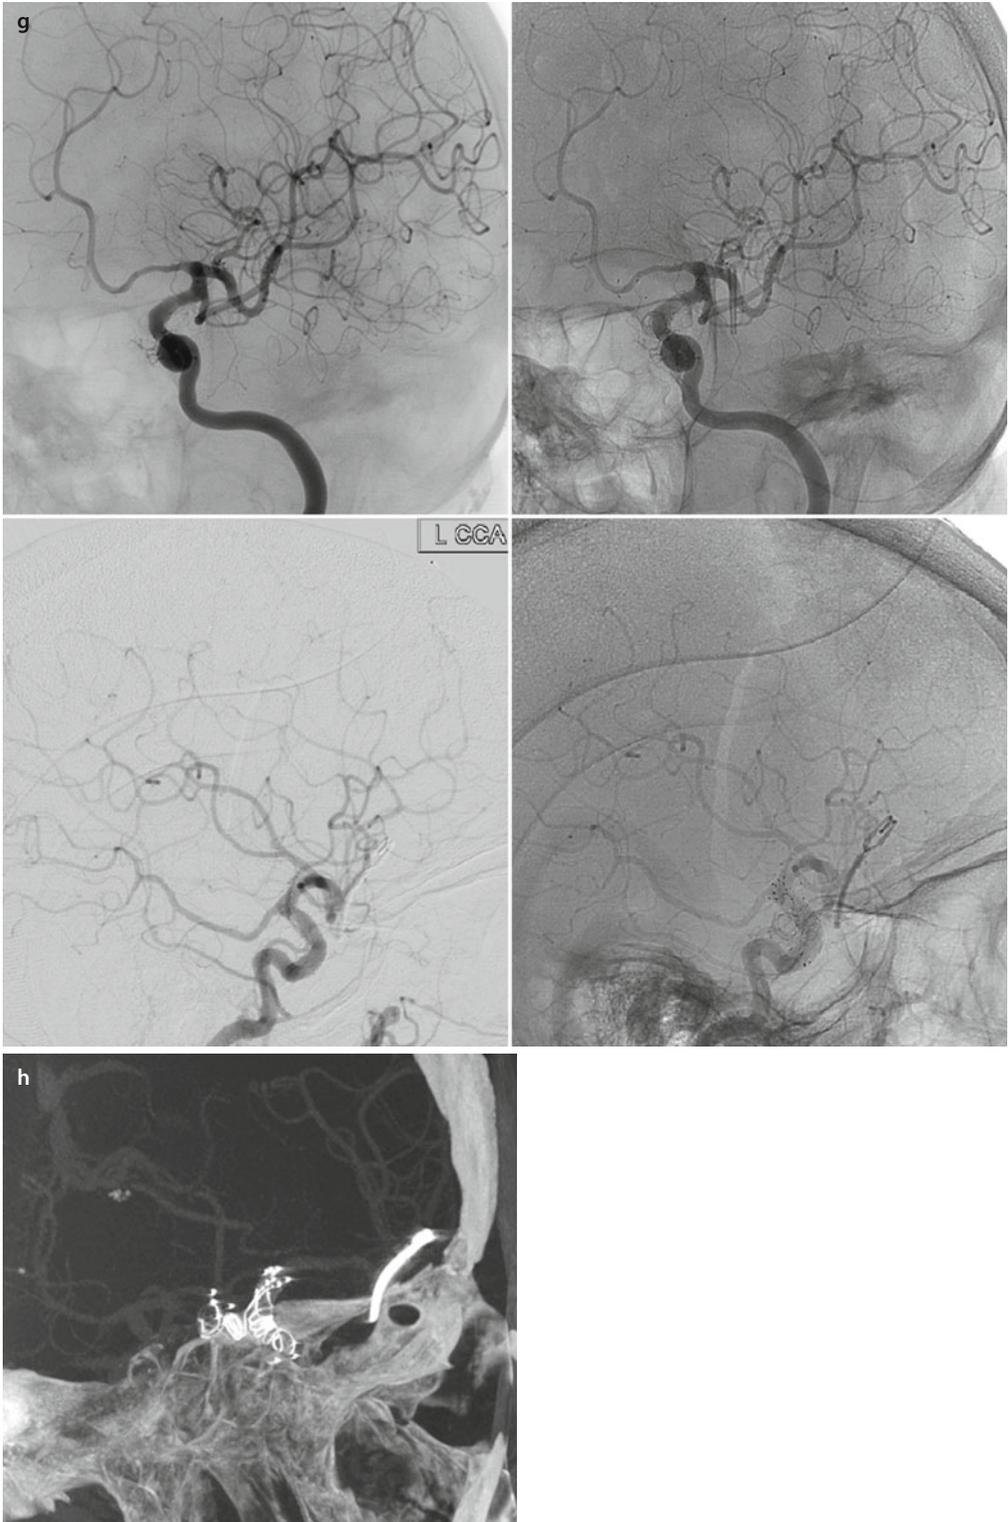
(continued) (g, h). Follow-up 6-month DSA and 2-year IV VASO CT® reveals complete aneurysmal exclusion and remodeled ICA.
